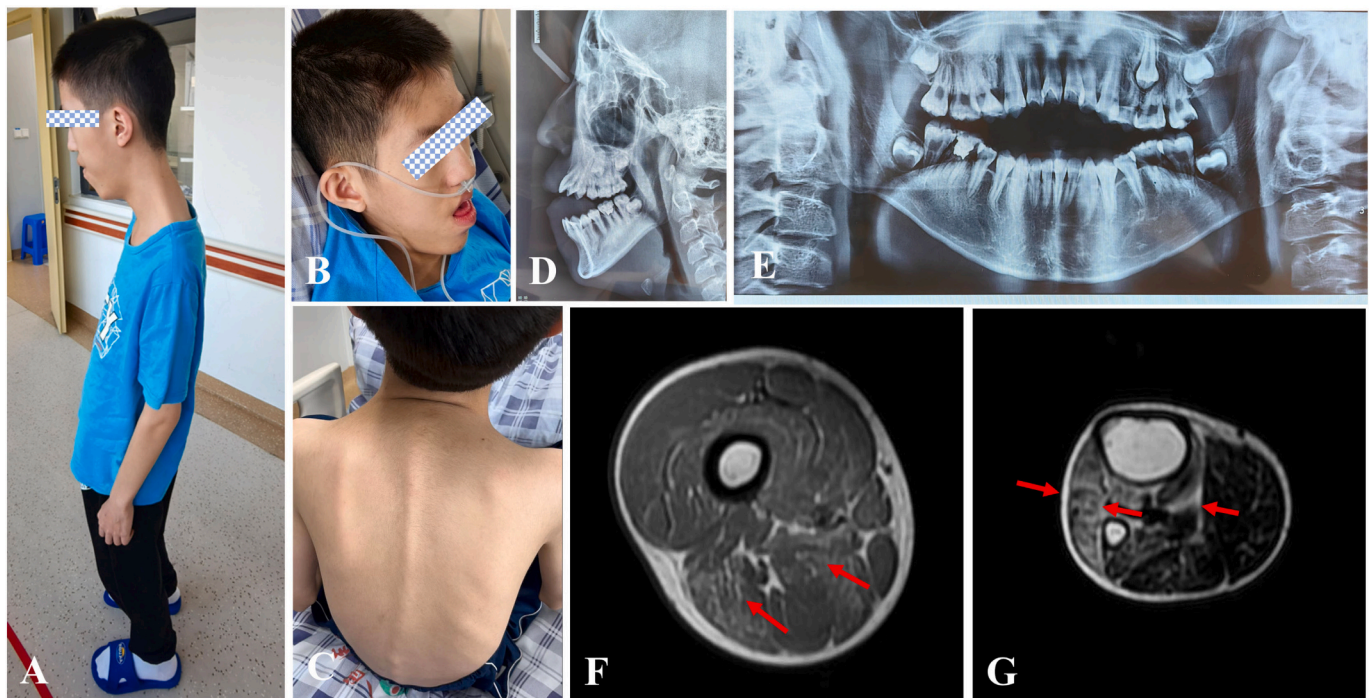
Clinical presentation and imageology analysis. Lateral and posterior images of the proband (A, B and C). Physical examination findings, (D and E) X-ray images of teeth, (F) Right thigh MRI scans of the patient, fatty infiltration in the muscles and the muscle gaps (arrow), (G) Right calf MRI scans of the patient, fatty infiltration in the muscles and the muscle gaps (arrow).
